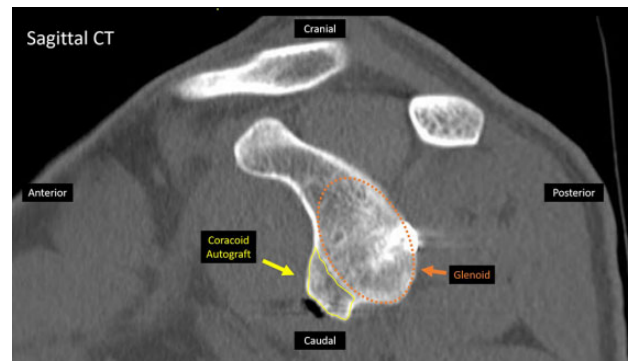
Sagittal computed tomography (CT) image at the level of the glenoid in an 18-year-old man demonstrates 100% osseous bridging at the autograft–native glenoid interface at 12 weeks postoperatively after nonrigid suture fixation using a cortical button device. No graft migration was seen in this patient.
